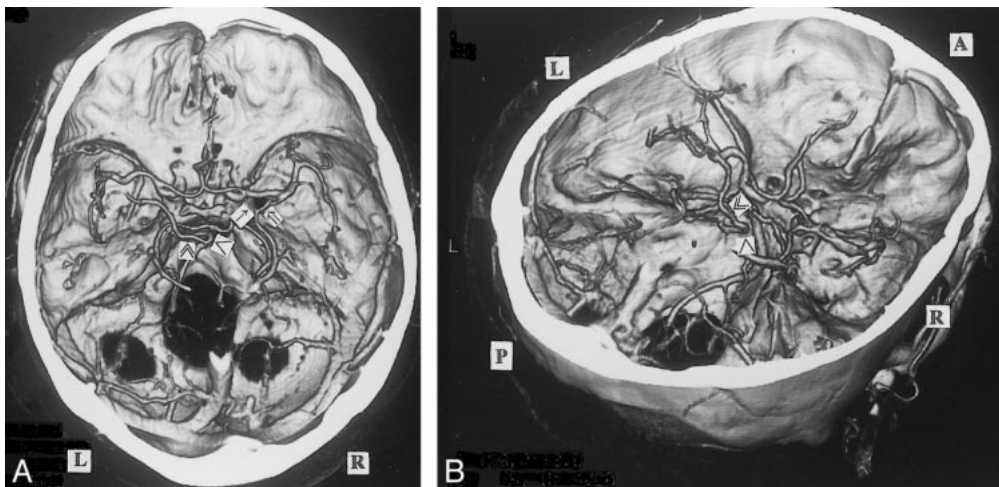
A, 3D CT angiogram (axial view) and B, right posterosuperior oblique view. The left BVR enters the superior petrosal sinus via the peduncular vein (\gg) and anterior pontomesencephalic vein ($>$). The right first segment is formed from the union of the deep middle cerebral vein (\Rightarrow) and the anterior cerebral vein (\uparrow).
